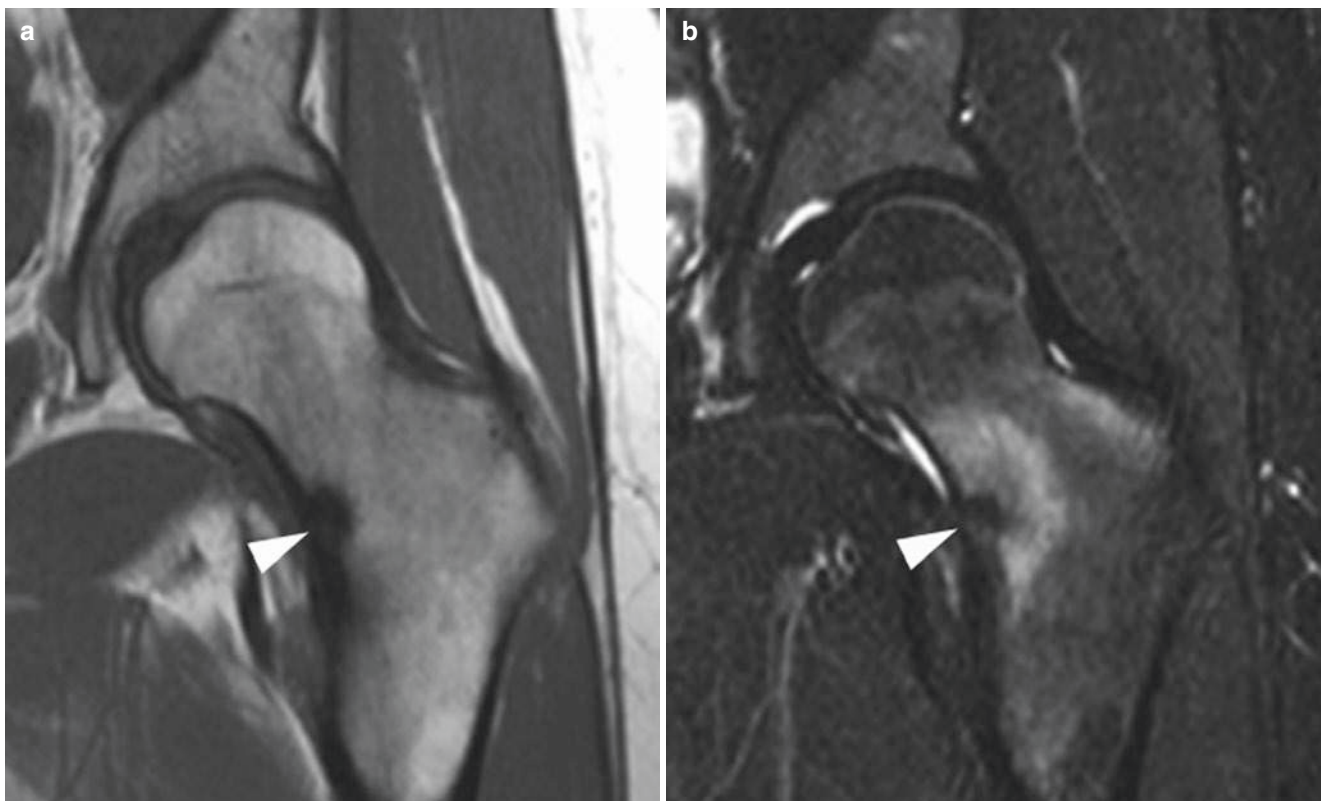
(a, b) Inferomedial fatigue fracture of the femoral neck. (a) Coronal T1-weighted TSE image and (b) corresponding STIR TSE image show a focal band of low signal intensity (arrowhead) perpendicular to the medial cortex surrounded by bone marrow edema
